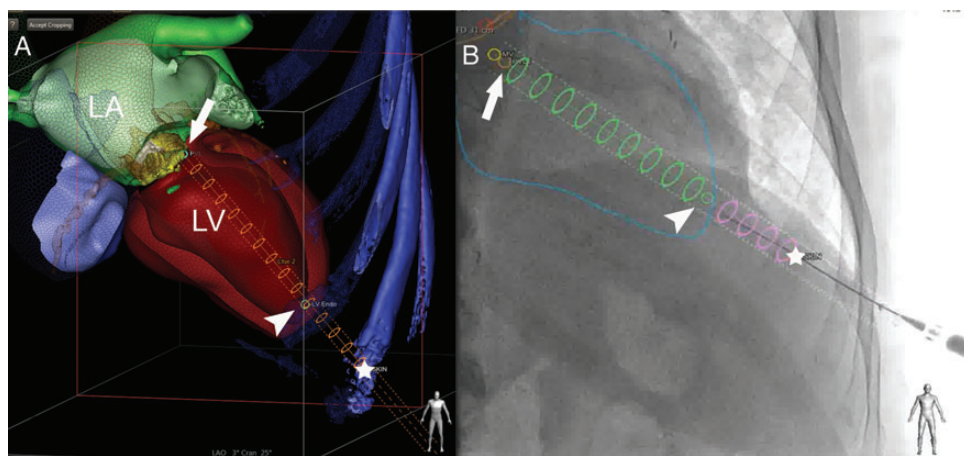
Cardiac computed tomography and fluoroscopy fusion: the landmarks noted on the Cardiac computed tomography imaged (A) are demonstrated on the fluoroscopy screen (B). (star: site of skin puncture, arrowhead: site of left ventricular apical puncture, arrow: site of the paravalvular leak. Note the straight path from the skin to the target (paravalvular leak) (see also text). Other abbreviations: LA, left atrium; LV, left ventricle.
